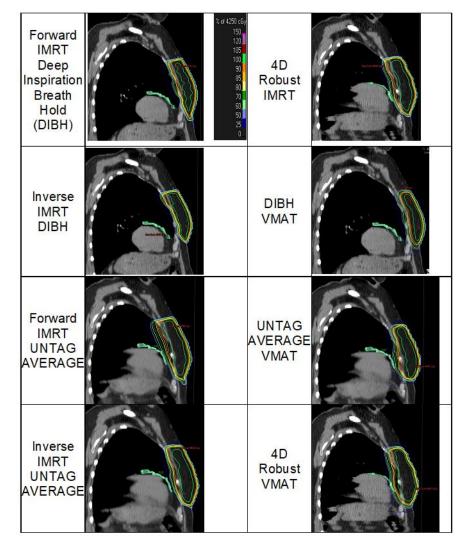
Whole-breast radiation treatment methods, with corresponding dose distribution of a representative left-sided breast cancer patient. The left anterior descending artery was three-dimensionally segmented in green on each CT image. Note that the 4D Robust and UNTAG AVERAGE radiation treatments were planned on the same 4D-CT dataset, but for simplicity, the dose distributions of 4D Robust technique were overlaid on the end-inspiration CT image of the 4D-CT dataset.
